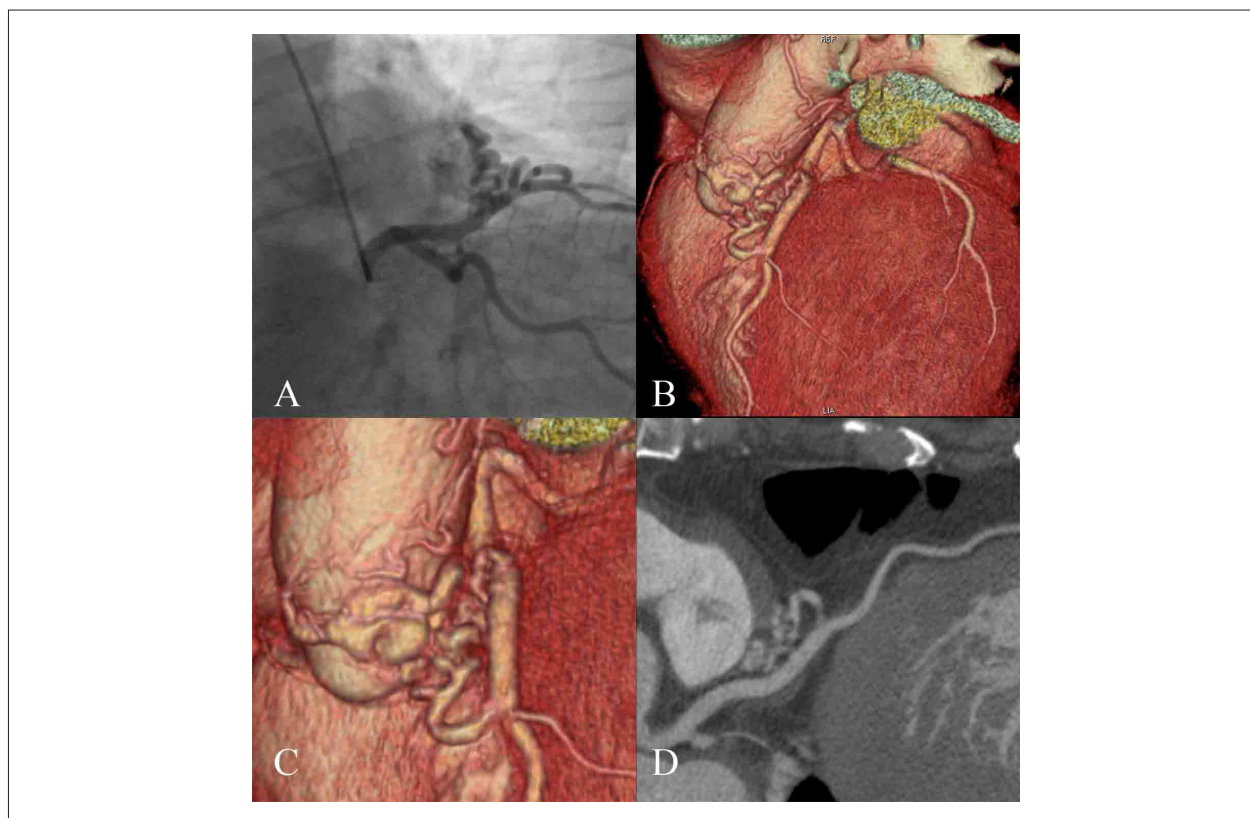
Coronary angiography (Panel A) and Multi-detector-row computed tomography (Panel B, C and D) showing left anterior descending artery coronary fistula to pulmonary artery.
